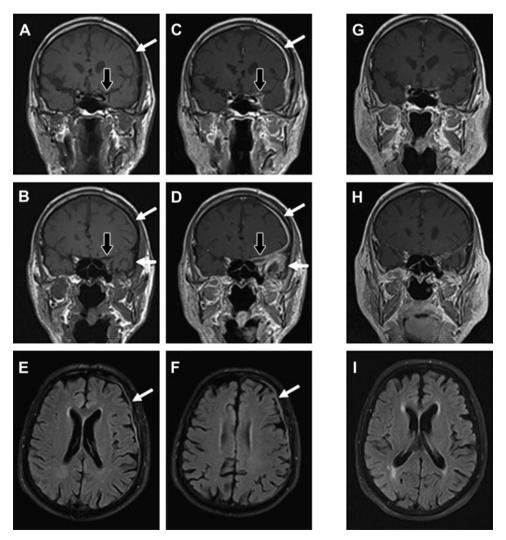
MRI at 3T performed before (A—F) and 8 months after initiation of corticosteroid therapy (G—I). Coronal native T1-weighted scans (A) show hypointensity and bulging of the left cavernous sinus extending into the orbital apex (B, black arrows) and diffuse broadening of the meningeal spaces of the left hemisphere (white arrows). All the hypointense structures are densely enhanced following application of contrast material (C, D) especially in the temporal fossa (D). Diffuse meningeal thickening is seen almost over the entire left hemisphere (E, F). Follow-up MRI shows marked regression of tissue masses and contrast enhancement (G, H) and signal hyperintensity of the meninges over the left hemisphere has disappeared (I).
